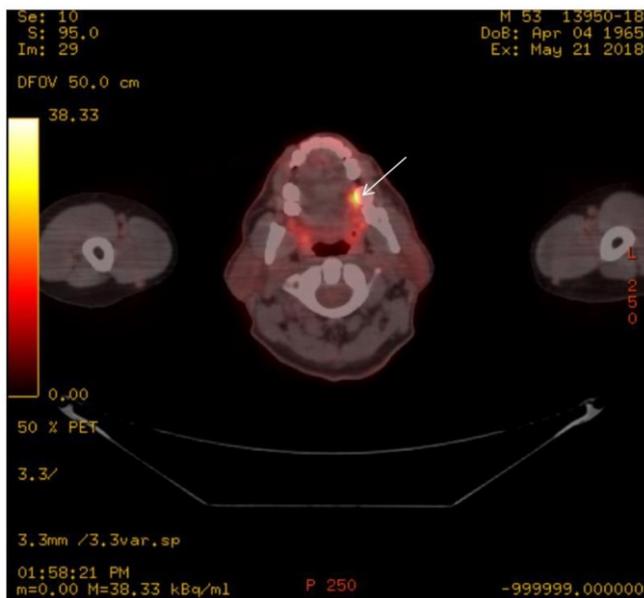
hypermetabolic lesion found is in the left side of the tongue SUV max 8 which is already diagnosed as squamous cell carcinoma
